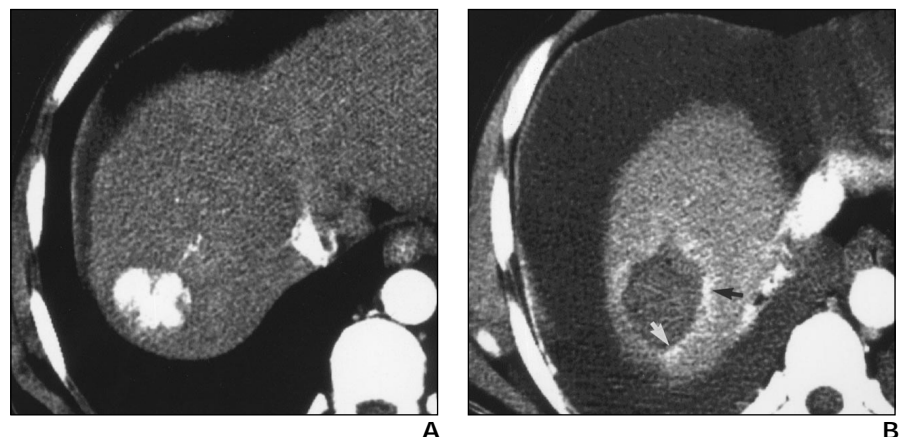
58-year-old man with hepatocellular carcinoma. A. Arterial phase CT scan of dome of right lobe of liver before ablation shows untreated solitary hypervascular tumor.
